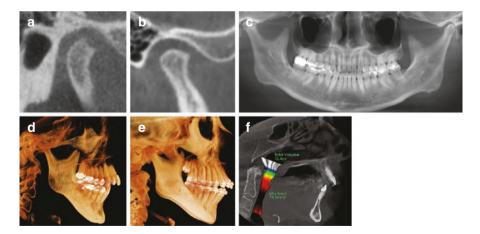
CBCT reformats for different patients with juvenile degenerative joint disease in the (a) active phase and (b) stable phase (note the location of the condylar heights of contours in relation to one another). Some of the skeletal and soft tissue changes that may occur with any condition that reduced the size of the condyle, including this one, are (c) marked mandibular asymmetry (if unilateral), (d) small posteriorly rotated mandible with high gonial angle and steep mandibular plane (if bilateral), (e) anterior open bite (can occur with posterior rotation of the mandible), and (f) small oropharyngeal airway (with small, posteriorly rotated mandible)
